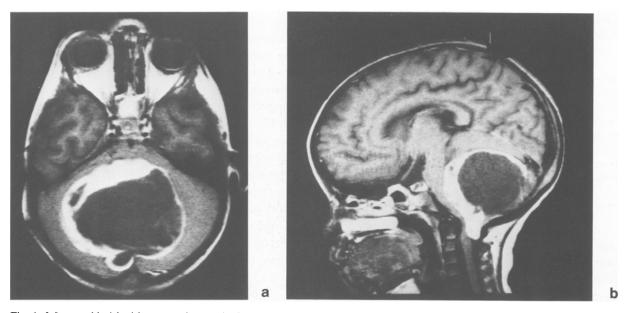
3.5-year old girl with progressive ataxia. Enormous smoothly delineated tumour in the posterior fossa (max. diameter 7 cm). The central cyst is surrounded by contrast-enhancing tumourous tissue of variable thickness. Note the herniation of tumour components through the foramen magnum. Elevation of the tentorium and compression of pons and medulla oblongata are caused by the tumour. (a) Axial and (b) sagittal T1-weighted SE (TR: 500 ms, TE: 30 ms)
